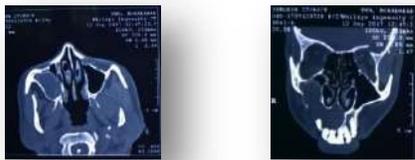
Axial and coronal CT showed a large expansile lesion
